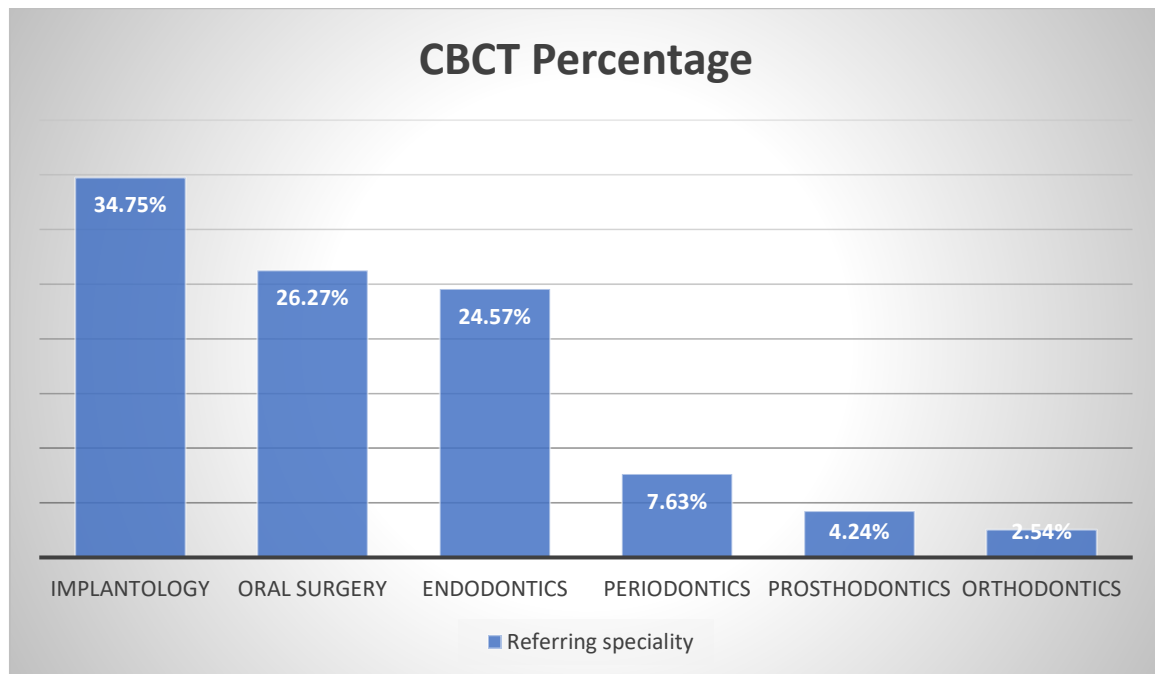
Distribution of patients referred for CBCT investigation across different dental specialties in the Jalgaon district.
